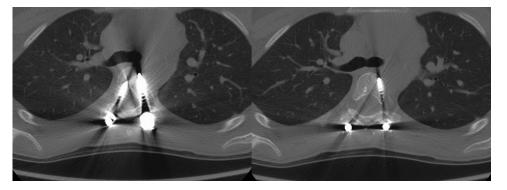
Two consecutive images from the postoperative computed tomographic scan obtained due to radicular symptoms correlating to malpositioned right upper instrumented vertebra screw, medially breaching the pedicle cortex.
